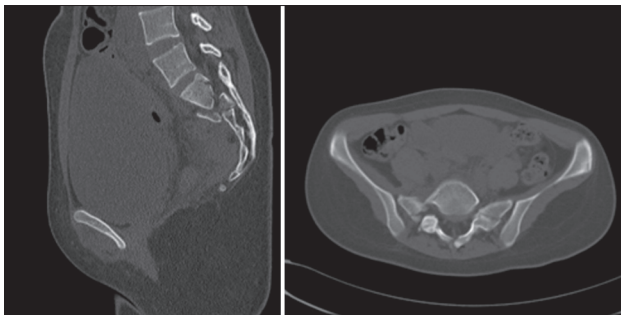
CT scan Sagittal and axial views are demonstrating bilateral transverse sacral fracture
